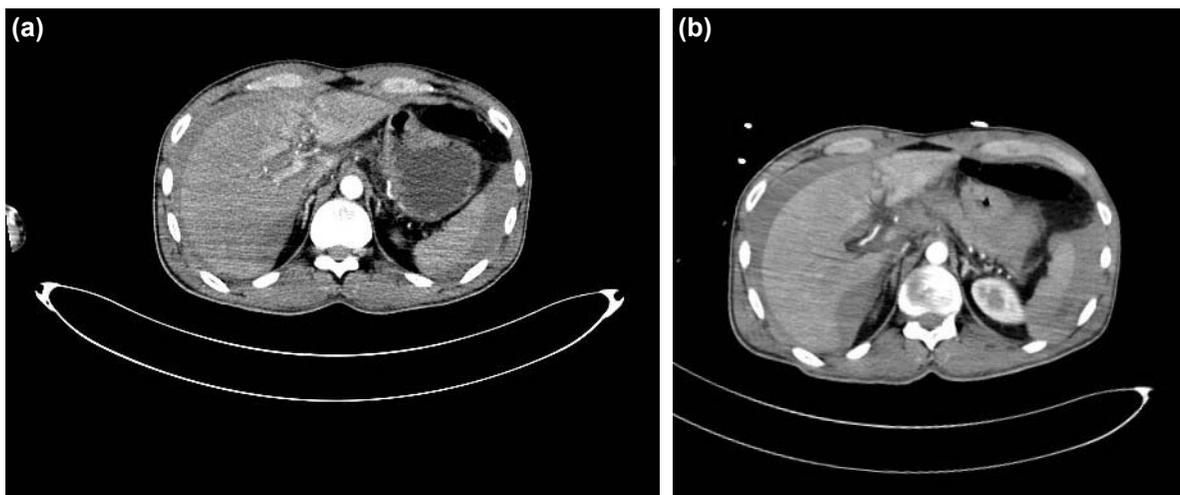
(a) An abdominal computed tomography scan image which acquired during admission. Image shows perihepatic fluid but no free air inside of abdomen. (b) An abdominal computed tomography scan image which acquired 4 h after admission. Image shows increased perihepatic fluid.
